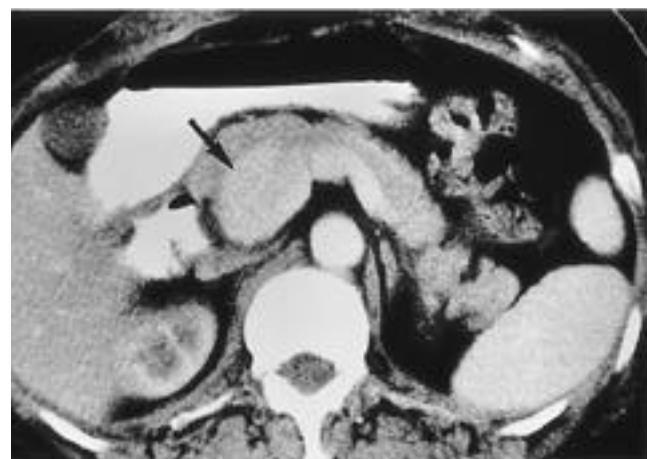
46-year-old woman with extrahepatic portal vein aneurysm. Portal-venous phase CT scan shows a cystic dilatation of the extrahepatic portal vein at the confluence of the superior mesenteric vein and splenic vein (arrow).
